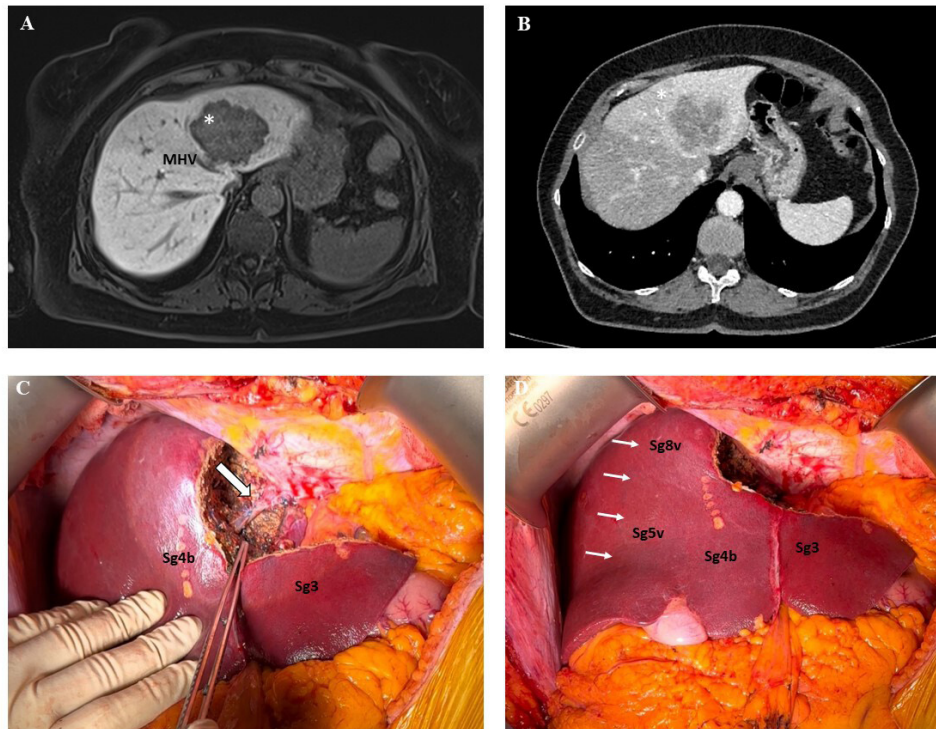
(A) The MRI scan of patient 6 shows a tumor in Sg2/4a (asterisk) involving MHV and LHV (not shown). (B) The arterial phase of the CT shows hyperattenuation of the left lobe due to the hepatic artery buffering response in the setting of chronic HVOO leading to portal hypoperfusion. (C, D) An operative field after the left upper transversal hepatectomy—Sg2, 4a en-bloc resection with MHV segmental resection and end-to-end reconstruction. White arrow: venous anastomosis. Thin white arrows: a demarcation line between chronic HVOO area (LHV and MHV drainage area) and parenchyma with preserved outflow (RHV area), which remained even after successful restoration of MHV flow. HVOO, hepatic vein outflow obstruction; LHV, left hepatic vein; MHV, middle hepatic vein; RHV, right hepatic vein.
